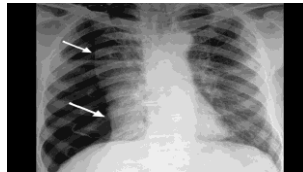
Lung Collapsed Represented by Arrows (Adopted from Dangila Primary Hospital X-Ray Room, 2012)
